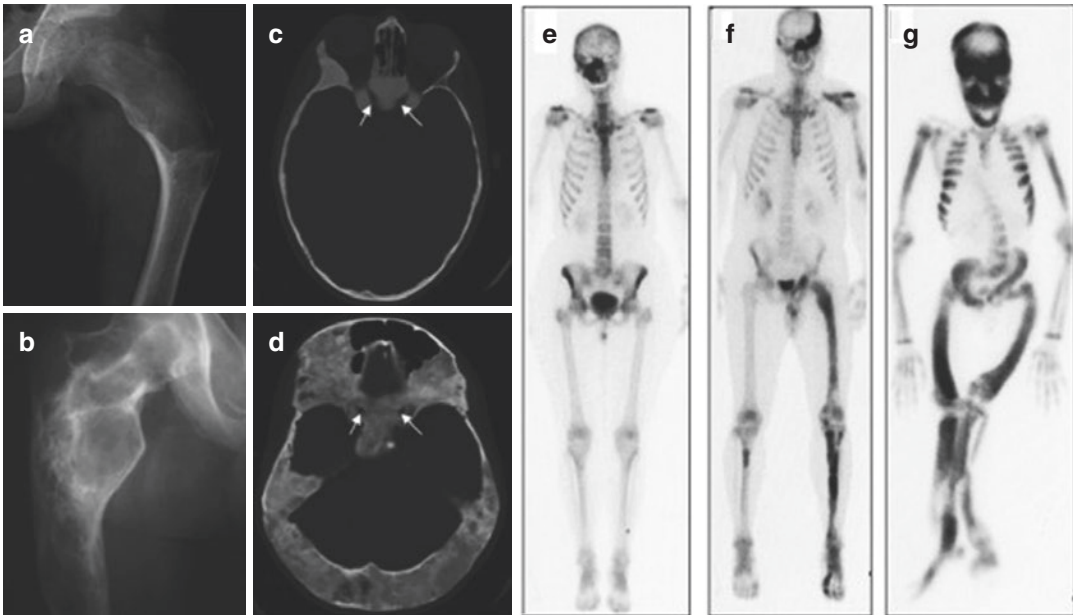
FD bone disease on radiographic and nuclear medicine imaging, (Dumitrescu and Collins 2008)
